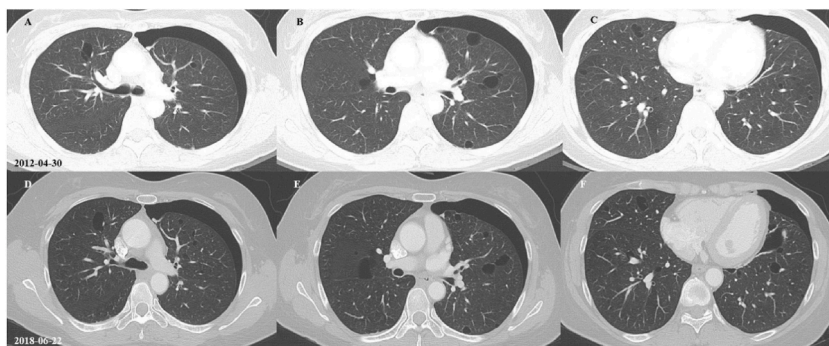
Axial chest CT images. (A)(B)(C) Chest CT scans of the initial spontaneous pneumothorax of the left lung in 2012. (D)(E)(F) Chest CT scans of the proband six years after her second diagnosis as spontaneous left pneumothorax. In comparison with the previous CT findings, slightly larger, multiple, thin-walled cysts are observed in both lungs, suggesting multicystic lung disease.
